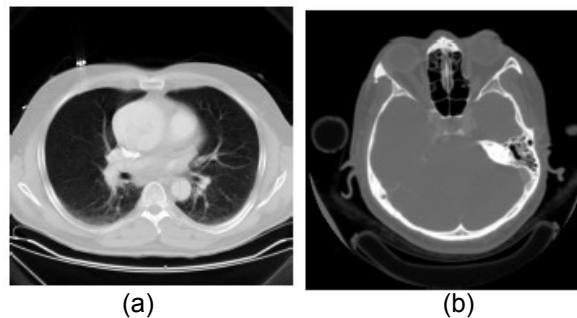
CT images (a) Transaxial CT lung slice. (b) Transaxial CT head slice [19].
